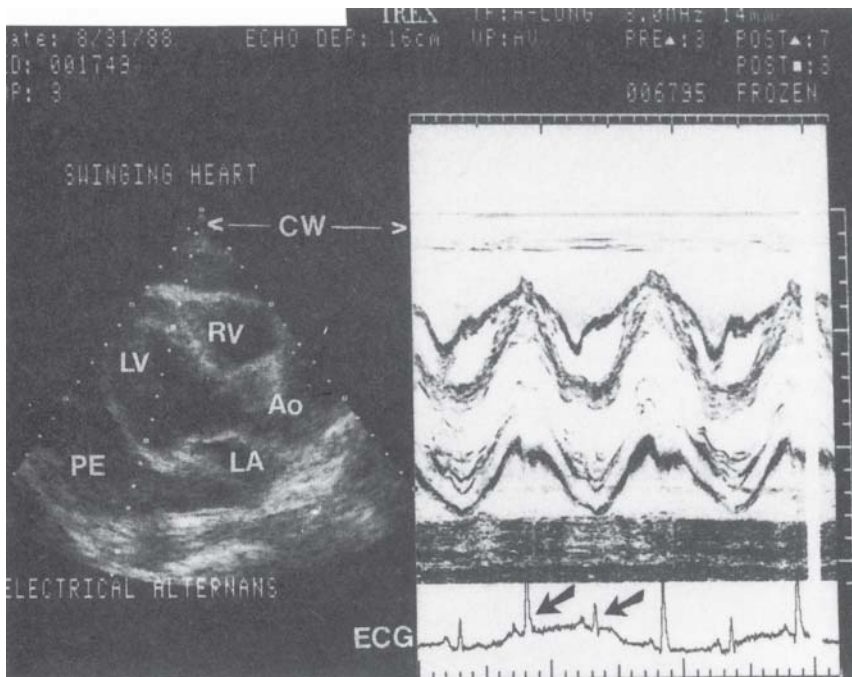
Cardiac tamponade in a patient with carcinoma of the lung. M-mode and two-dimensional echocardiogram reveal a large pericardial effusion with a swinging heart motion, diastolic collapse of the right ventricle and left atrium and electrical alternans. Note in the M-mode tracing that when the cardiac wall swings anteriorly, the QRS voltage is high (arrow) and low (arrow) when it swings posteriorly. Ao, aorta; RV, right ventricle; LV, left ventricle; LA, left atrium; PE, pericardial effusion; CW, continuous wave. From Gazes PC. Clinical cardiology. Philadelphia: Lea & Febiger, 1990, p. 374. Reprinted with permission.
